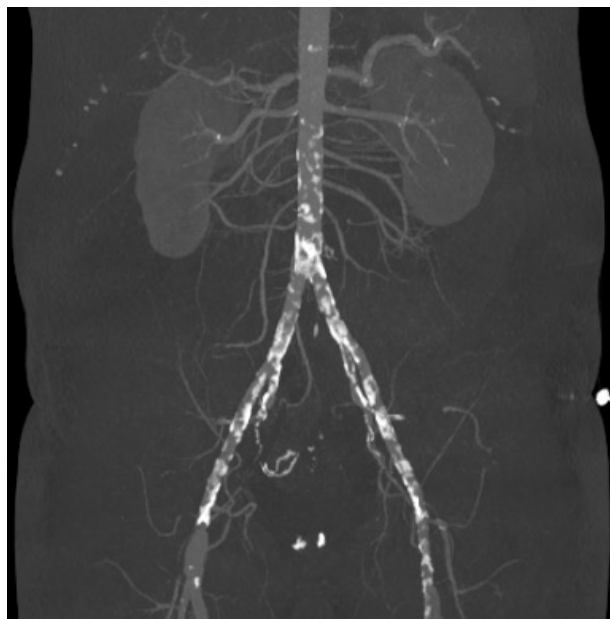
CT demonstrating severe bilateral iliofemoral calcific disease.
